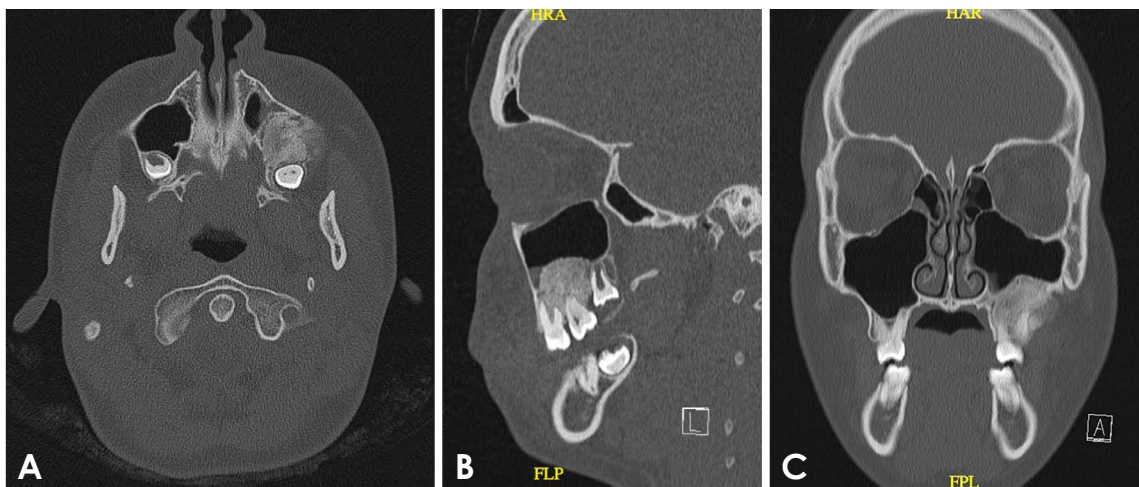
A. Axial computed tomography (CT) image shows an ill-defined area of hyper-attenuation with a ground-glass appearance involving the left maxilla. Note a thin hypo-attenuating band at the medial periphery. B. Sagittal CT image shows an ill-defined area of hyper-attenuation with a ground-glass appearance involving the left maxilla. Note the directional external root resorption of the maxillary first and second molars, and superior displacement of the left maxillary sinus floor. C. Coronal CT image shows an ill-defined area of hyper-attenuation with a ground-glass appearance involving the left maxilla. A thin hypo-attenuating band at the medial periphery is also appreciated. Note the directional external root resorption of the maxillary first molar, and superior displacement of the left maxillary sinus floor.
